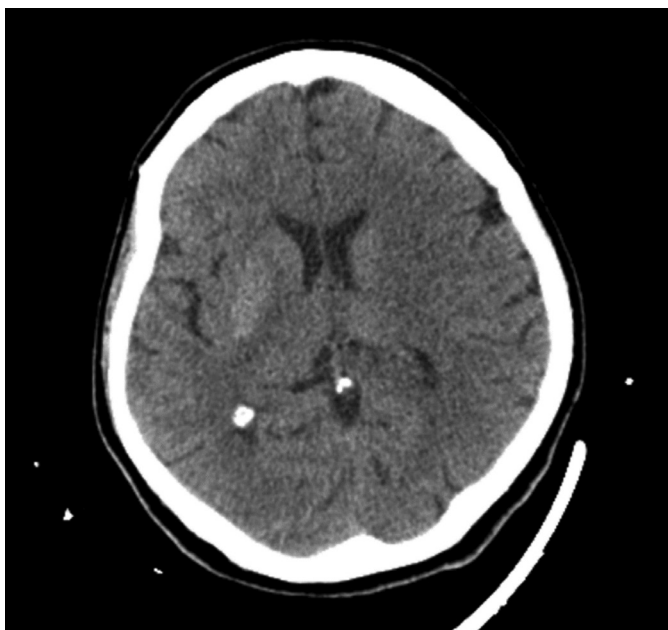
Non-contrast computed tomography demonstrates putaminal hyperdensity on the right hemisphere
